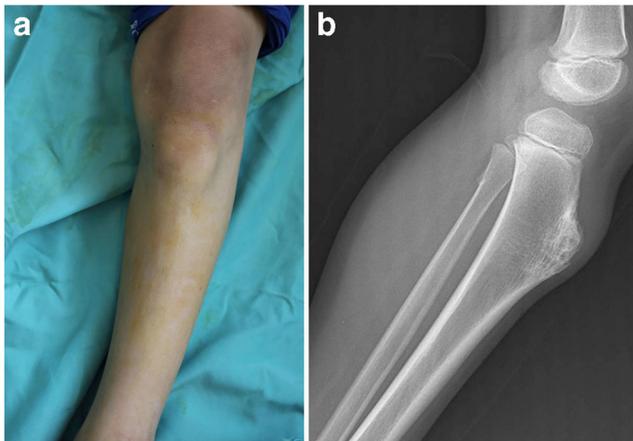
Osteochondroma mimicking Osgood-Schlatter's disease in a 9-year-old male (case 7). a Photograph of the involved knee showing a bump larger than general size in Osgood-Schlatter's disease. b Lateral radiograph of the lesion showing a protruded bone mass with cortical and medullary continuity with the tibial tuberosity consistent with broad-based osteochondroma
